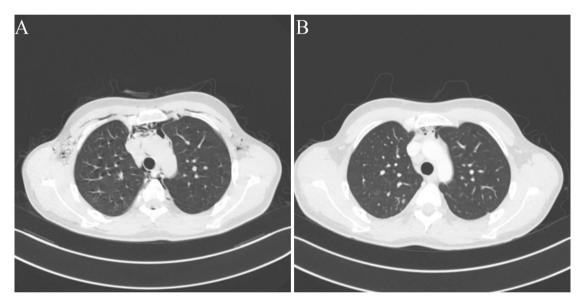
CT scan showing pneumomediastinum — at diagnosis (A) and (B) before discharge
